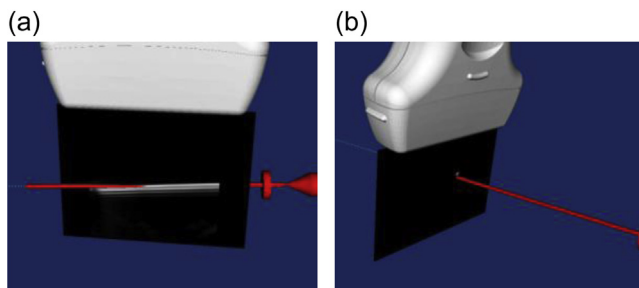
Two views (a), (b), depicting visualization of the relative pose between the tracked US probe and needle. When properly calibrated, the needle reflection in the sonographic image overlaps with the virtual representation of the needle.
